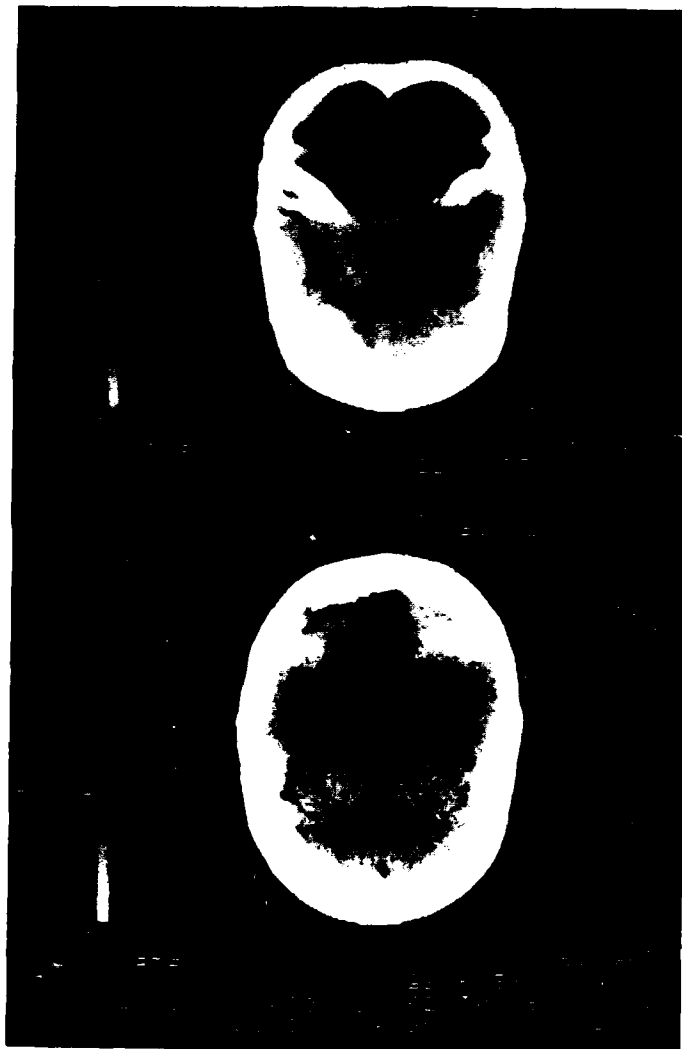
CT in a case suffering from Marie's spastic ataxia.
